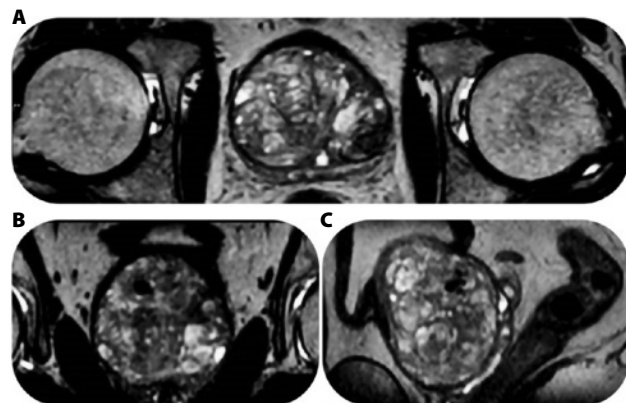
Three-dimensional T2-weighted axial (A), reconstructed coronal (B), and reconstructed sagittal (C) MR images of the prostate. Images courtesy of the author.
